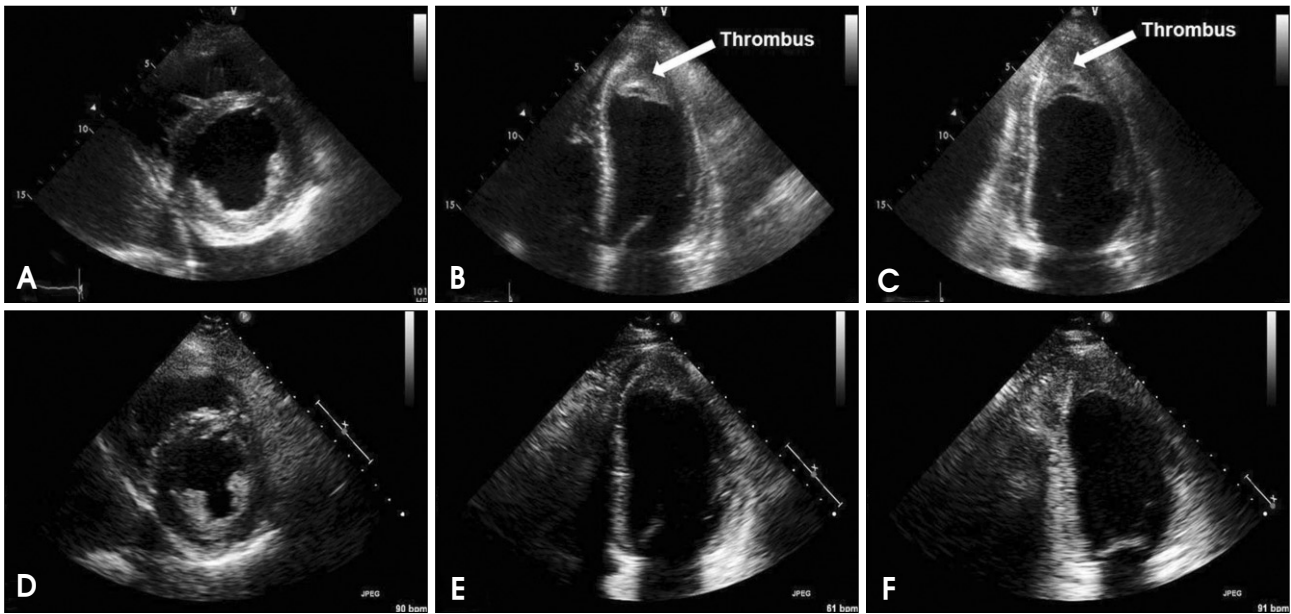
Initial transthoracic echocardiography shows mildly enlarged left ventricle with depressed ejection fraction, and echogenic thrombus (2.1×2.3 cm) in the apex (arrows) (A, B and C). Left ventricular function is improved and size of the apical thrombus is decreased after 2 months of treatment for Churg-Strauss syndrome (D, E and F).
